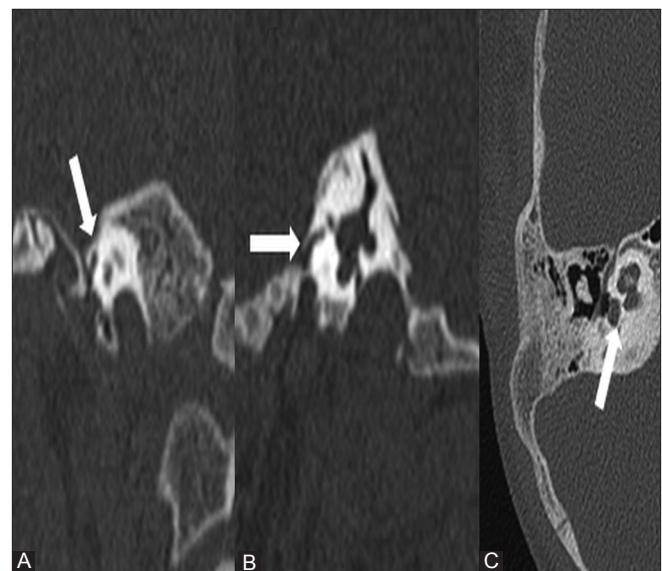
(A-C): Facial canal anomalies. (A) Coronal HRCT section shows anterior location of facial canal (arrow). Also note the shortened vertical course of the nerve. (B) Sagittal HRCT section of same patient shows similar findings (arrow). (C) Axial HRCT section shows intimate course of facial nerve to the round window (arrow)
